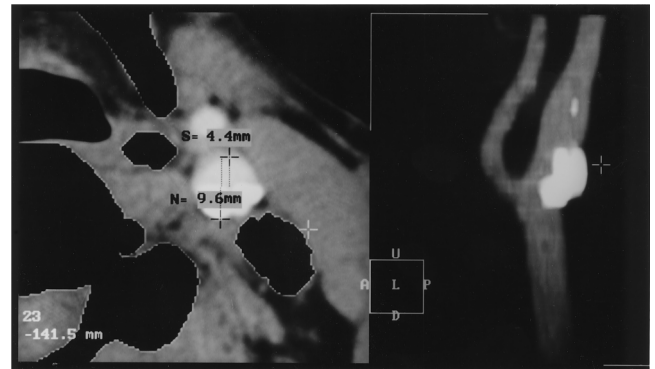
CT angiography of the left carotid bifurcation: calcified plaque of the internal carotid bulb.
